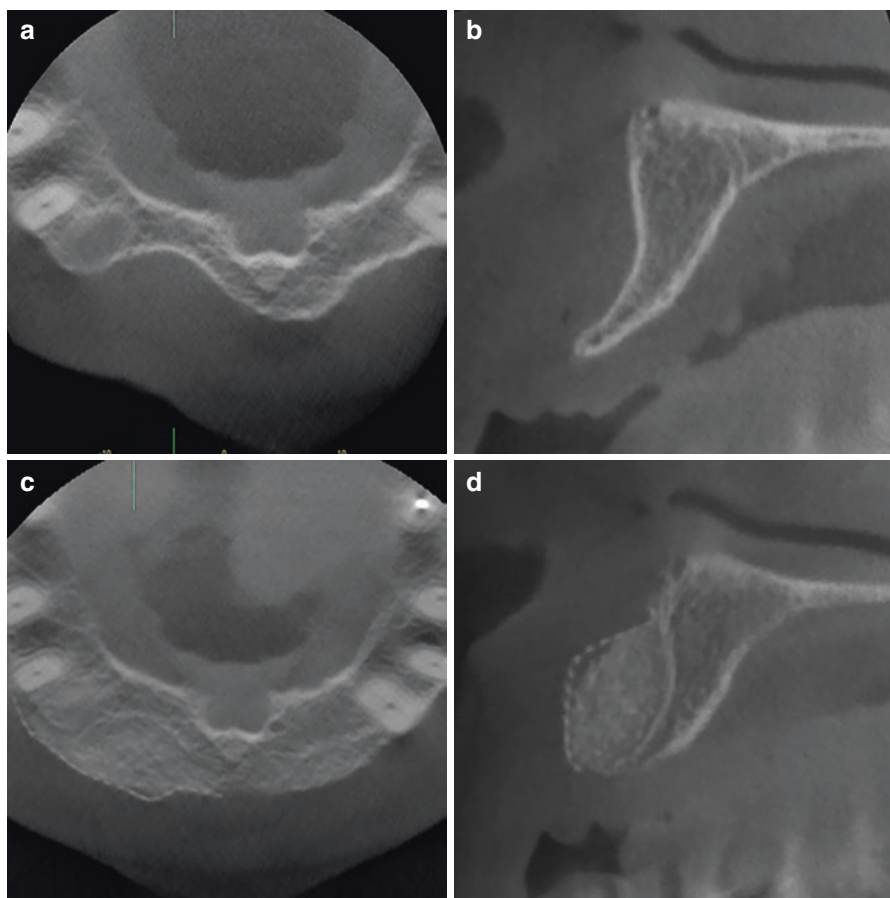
CBCT images pre- and post-lateral ridge augmentation. (a, b) Axial and sagittal images showing horizontal alveolar deficiency due to a pronounced buccal undercut in the lateral incisor area. (c, d) Axial and sagittal images after ridge augmentation showing well-adapted grafting material at the buccal aspect of the alveolar ridge supported by a non-resorbable membrane
